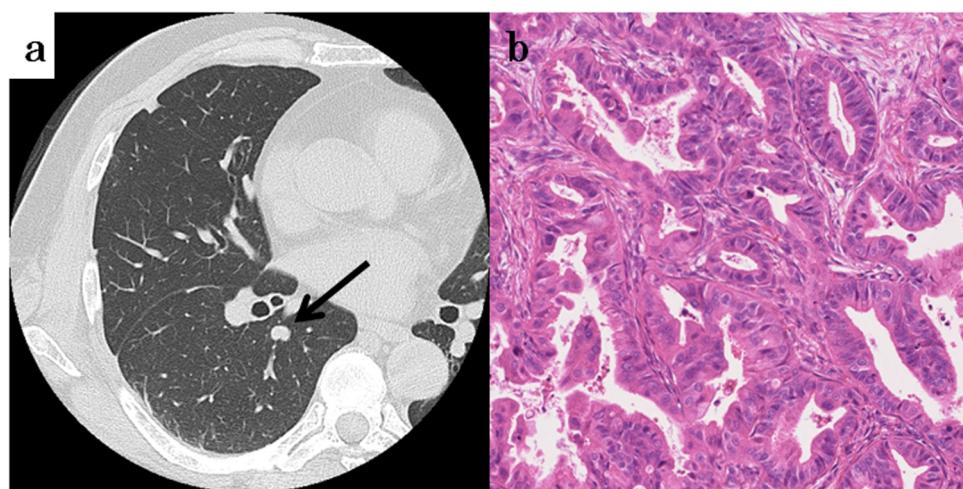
Chest computed tomography revealed a 0.9-cm nodule (coin lesion) in the right lower lobe (a, single arrow). Pathological examination indicated moderately differentiated adenocarcinoma (b).
